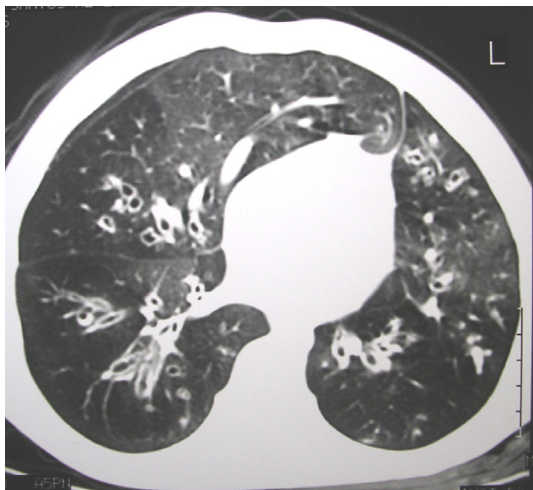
HRCT of a pediatric patient with post-infectious BO.
